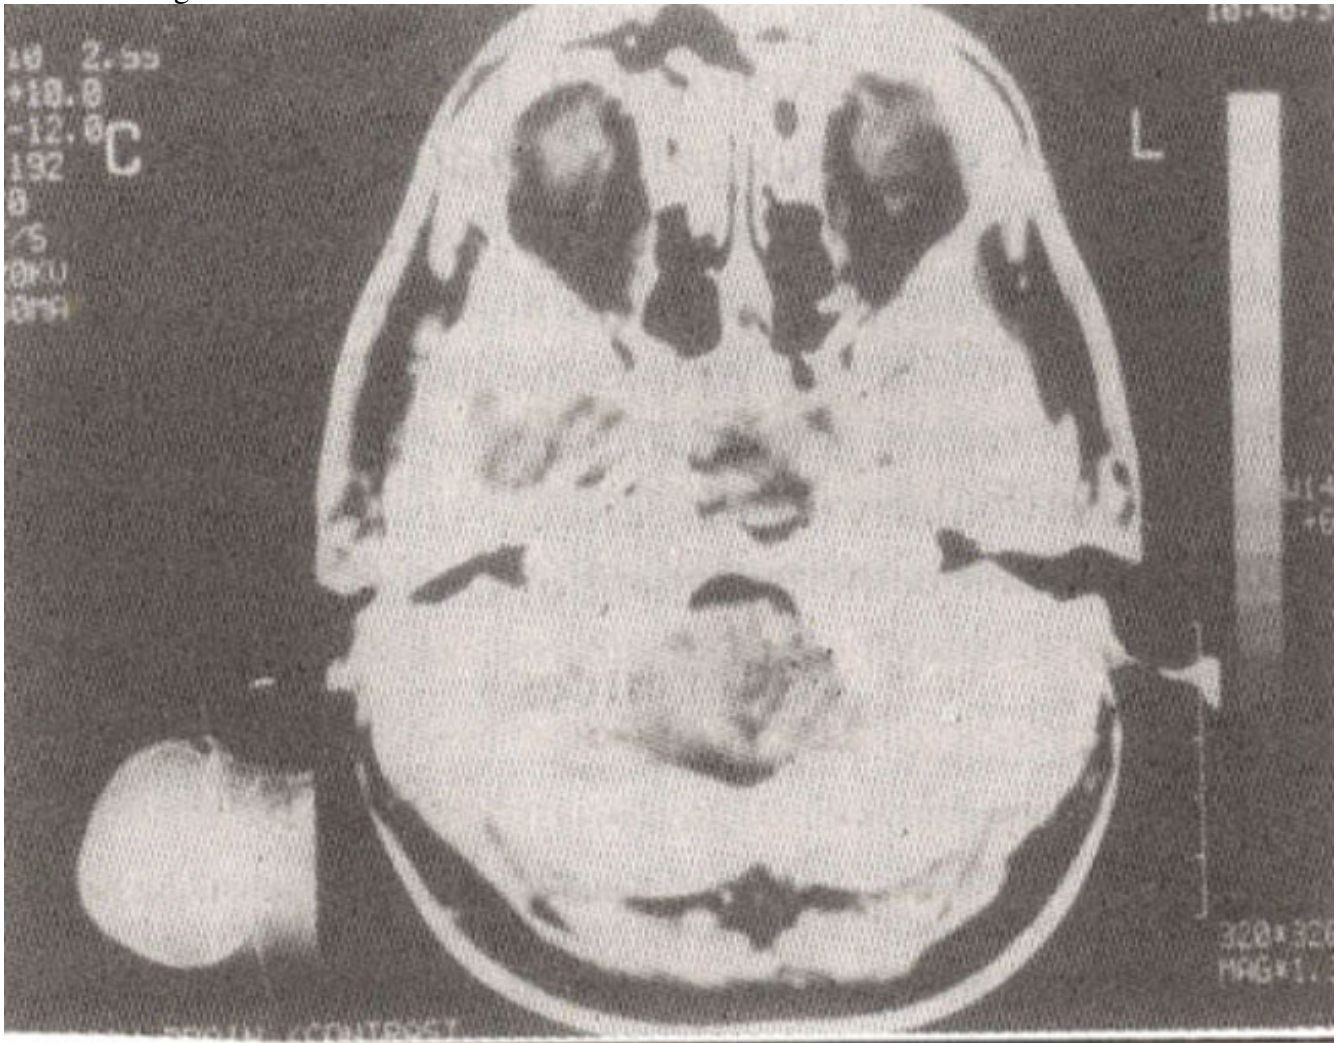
CT scan showing the soft tissue mass in the sphenoid with extension into the clivus
